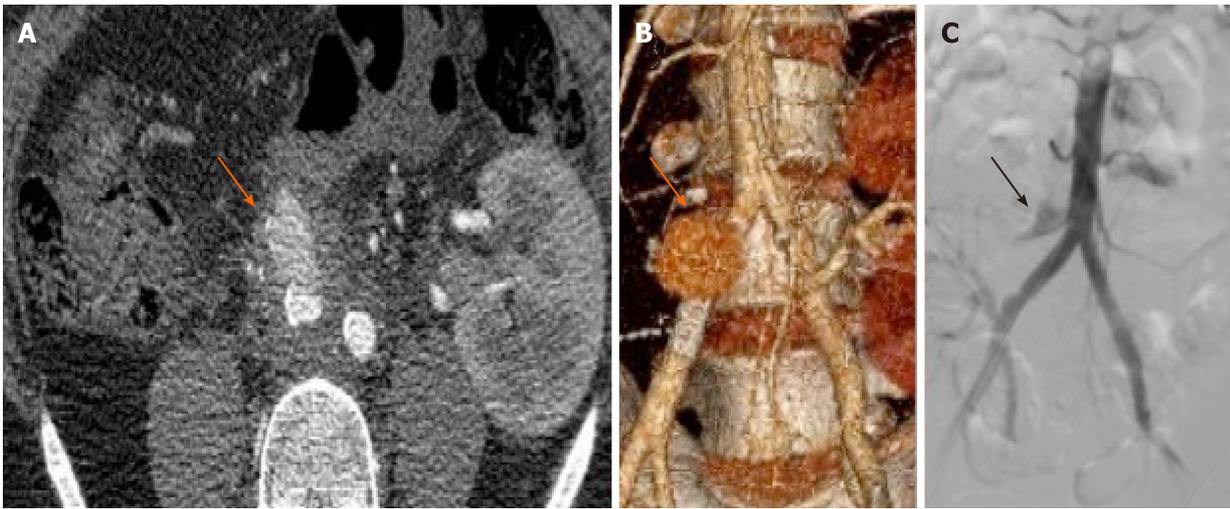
Pseudoaneurysm in the right iliac artery anastomosis of the pancreas graft in a simultaneous pancreas and kidney patient (arrows). A: Angio-computed tomography; B: Three-dimensional reconstruction of iliac artery and pseudoaneurysm; C: Angiography, arterial contrast filling the cavity of the pseudoaneurysm.
